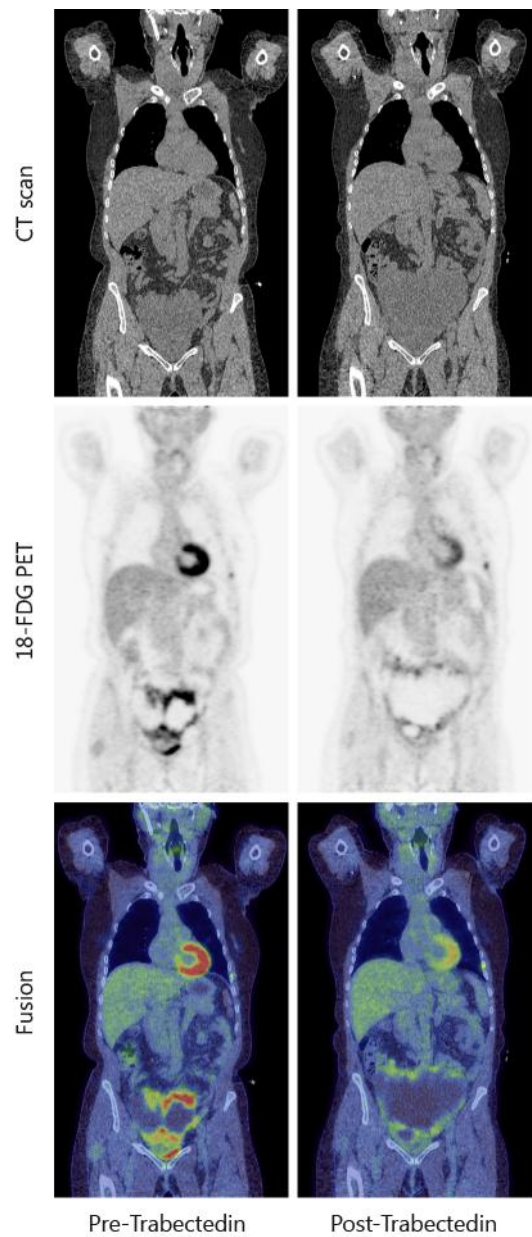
Comparison of ^{18}F FDG-PET-CT images before and 3 months after treatment with 3 cycles of trabectedin. There is expansion of the mass in the pelvis, with reduced ^{18}F FDG uptake and formation of a larger cystic/necrotic cavity within the mass. Note the left rib lesion. The PET images and fused PET-CT images are on an identical SUV 0–6 scale.
